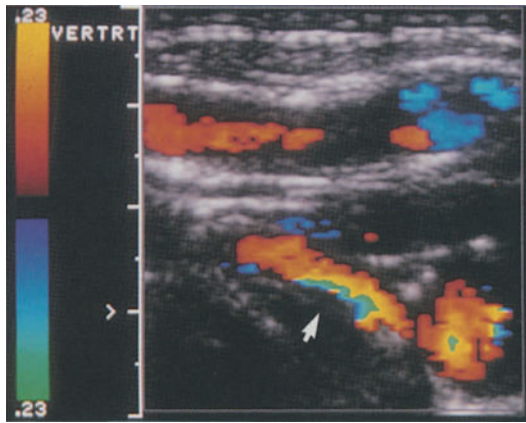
(left) Proximal portion of VA in longitudinal color-coded Doppler sonogram; note atheromatous lesions of posterior wall without significant stenosis (arrow)
